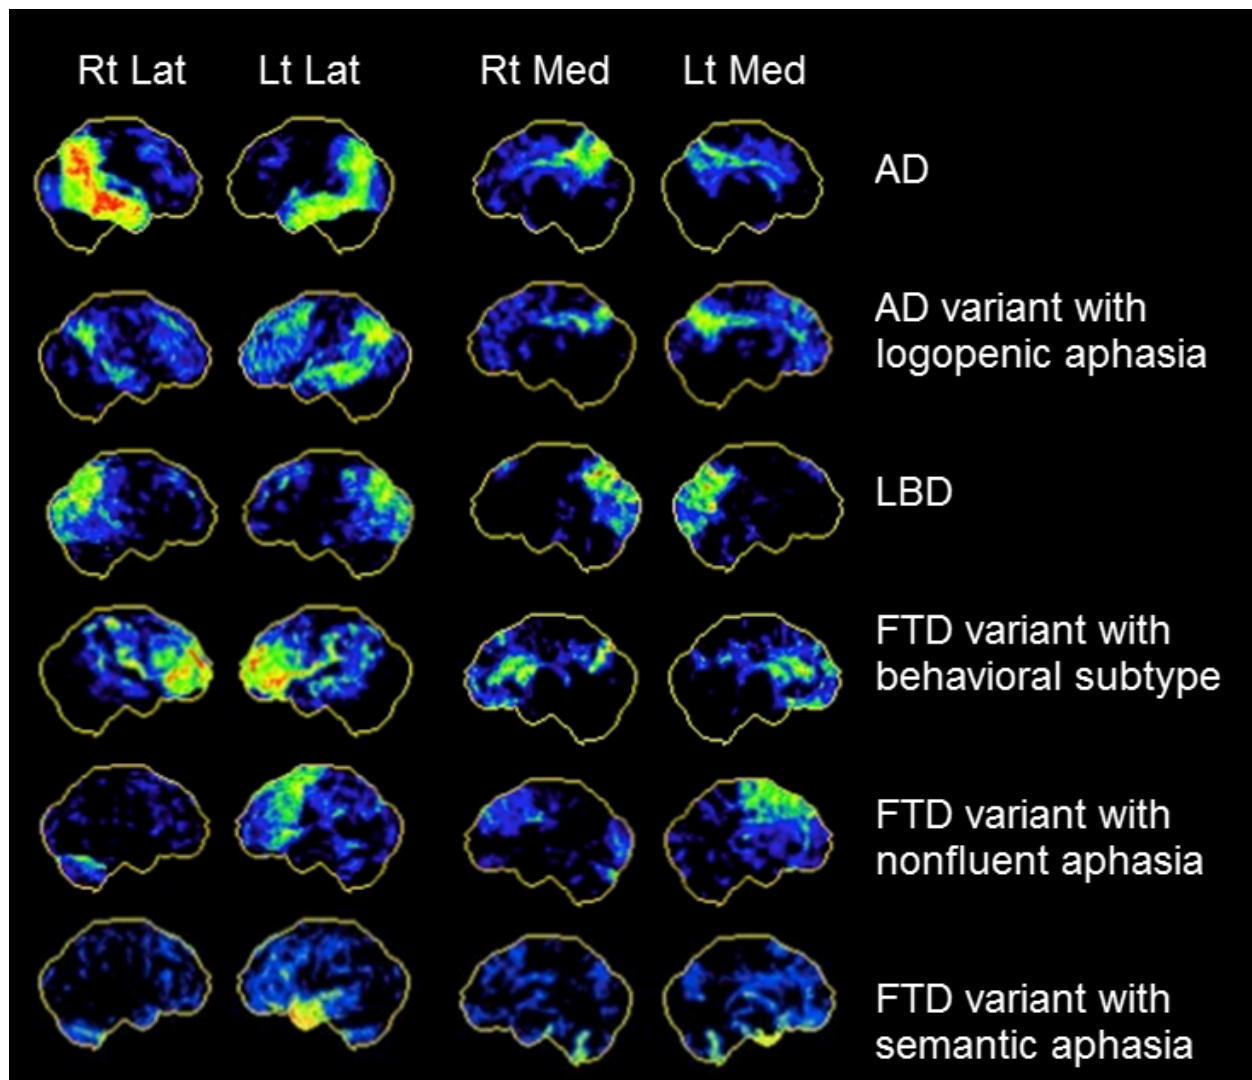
FDG-PET scan patterns displayed in NeuroStat 3D-SSP for focal onset dementias.
